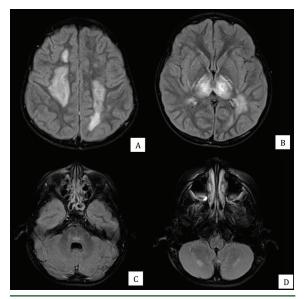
Axial T2/FLAIR images showing patchy confluent hyperintensities with involvement of the bilateral frontal and parietal lobes (A). Relatively symmetrical involvement of the thalami, midbrain, pons and cerebellar hemispheres were observed (B-D).
